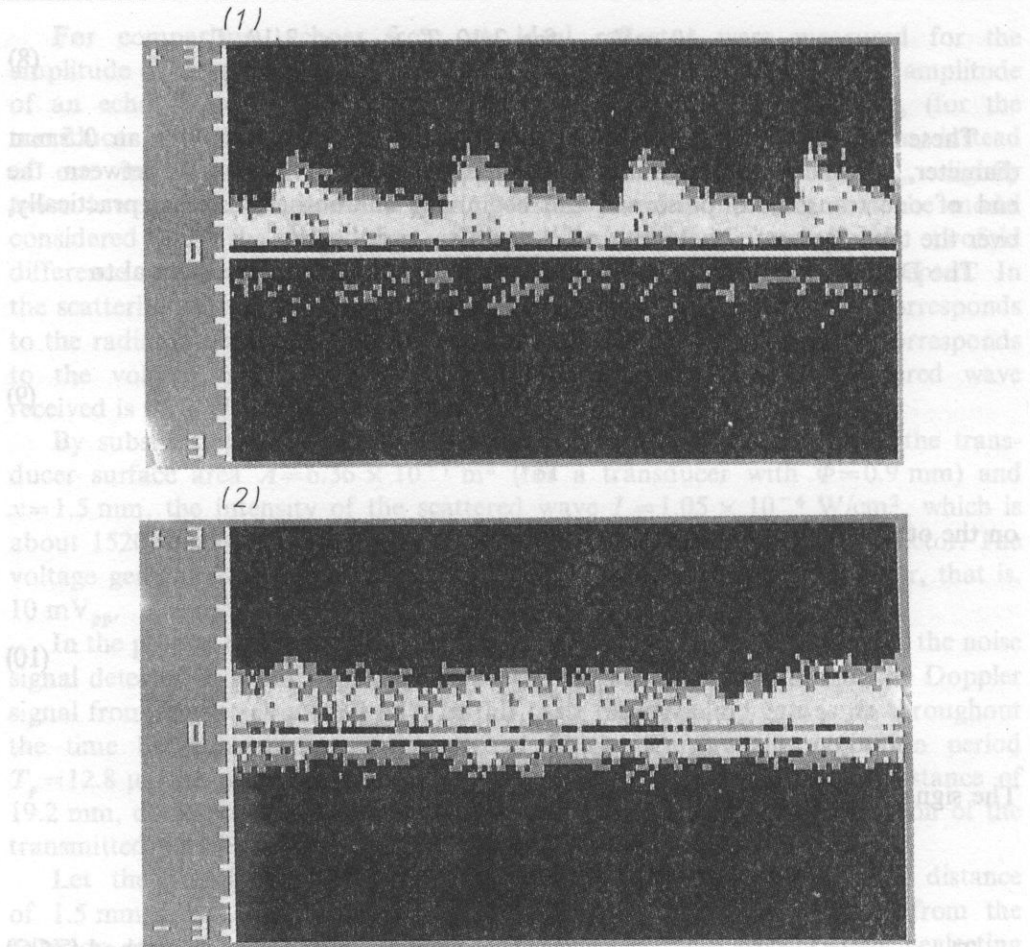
Spectra of Doppler blood flow signals recorded subcutaneously at 1) digital artery at 2.5 mm depth, 2) hand vein at 2 mm depth.
